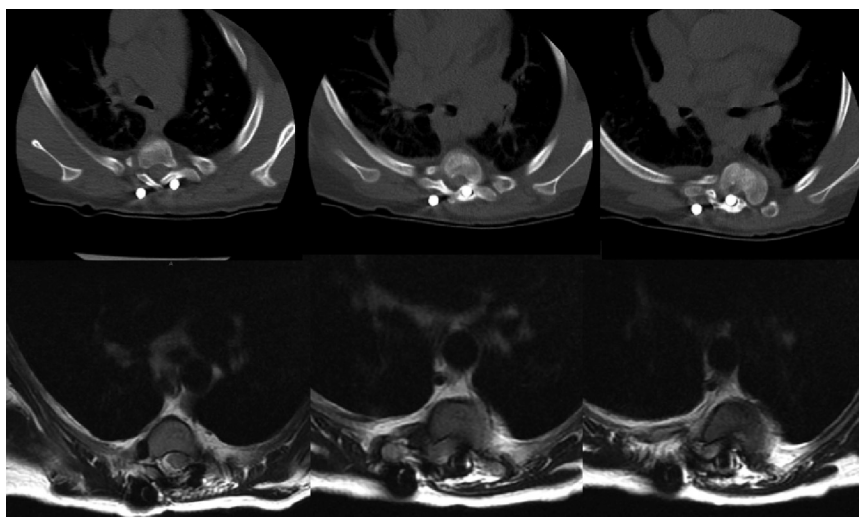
Axial computed tomography (CT) scan cuts and magnetic resonance imaging (MRI) T2-weighted images demonstrating the left rod eroding through the lamina at the apex of the thoracic deformity and encroaching on the spinal cord.
